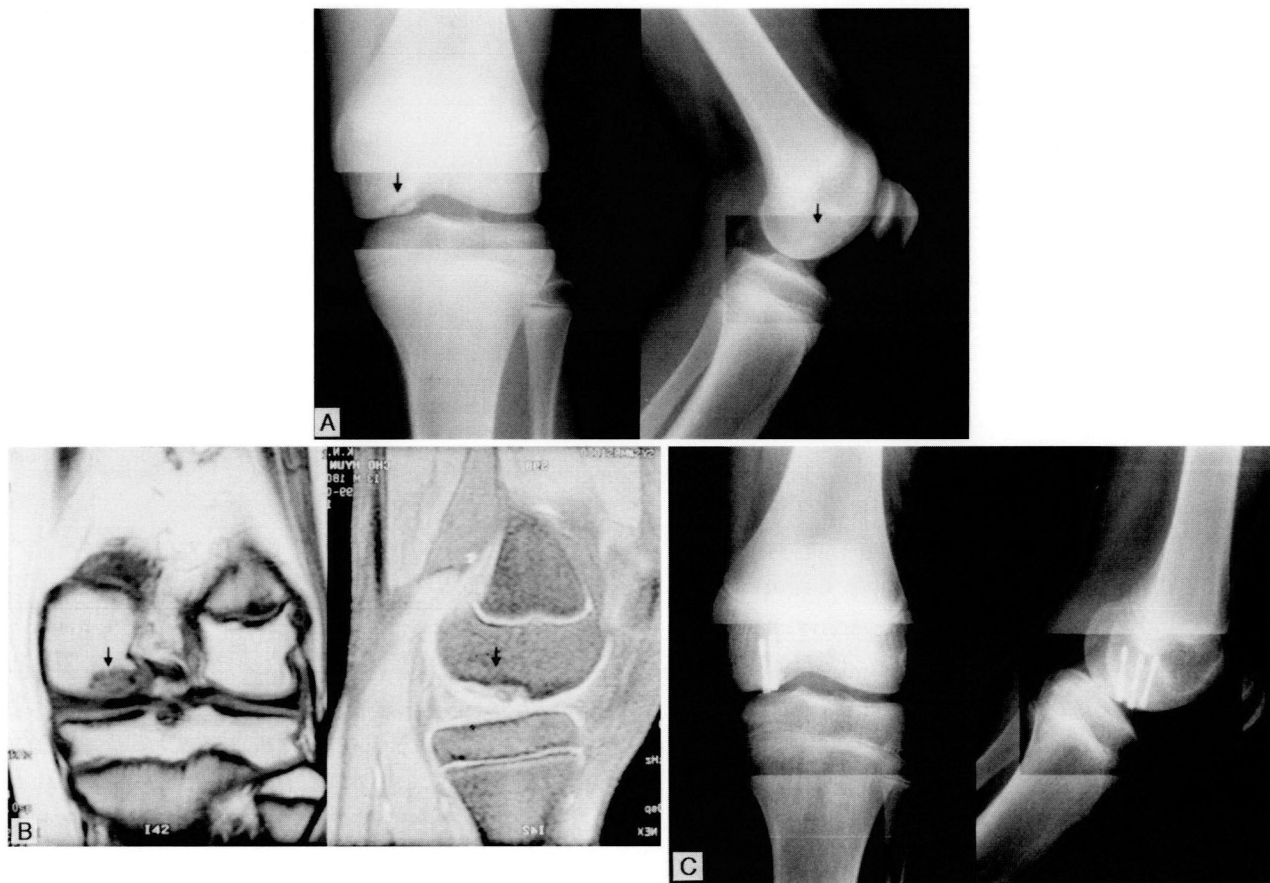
A : Simple X-ray of a 13-year-old boy shows a nearly-detached osteochondral lesion in the medial femoral condyle.
